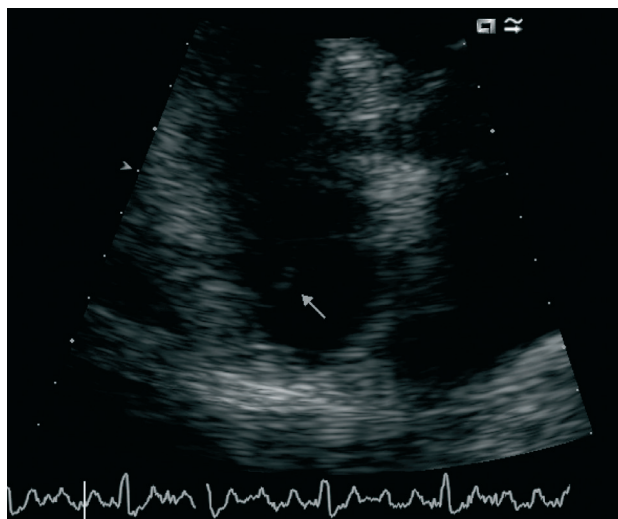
Transthoracic echocardiography. Enhanced image of the right atrium in apical plane, showing a filamentous structure consistent with Chiari's network.
